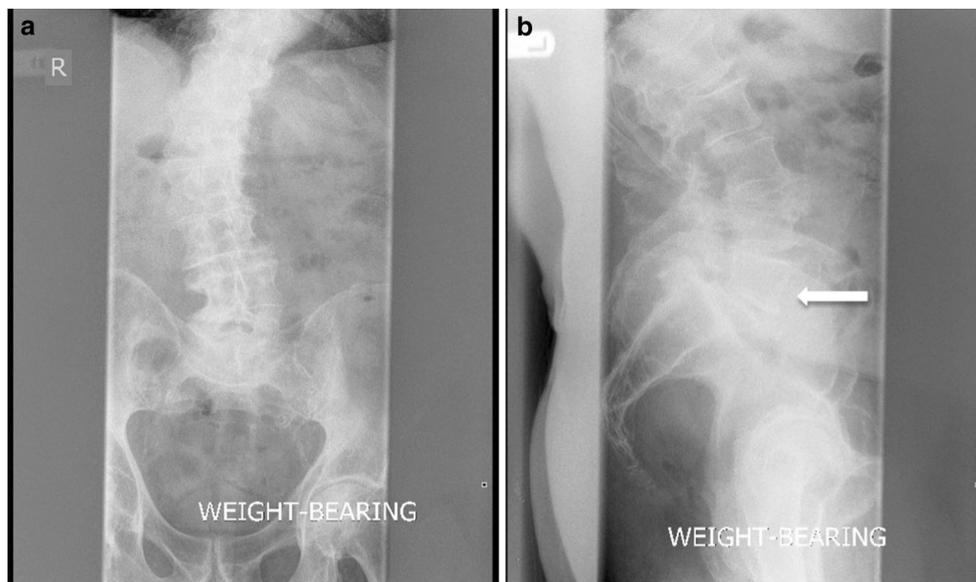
Preoperative standing a anteroposterior (AP) and b lateral plain radiographs of our patient. The listhesis of L5 on S1 is indicated by the *white arrow*
